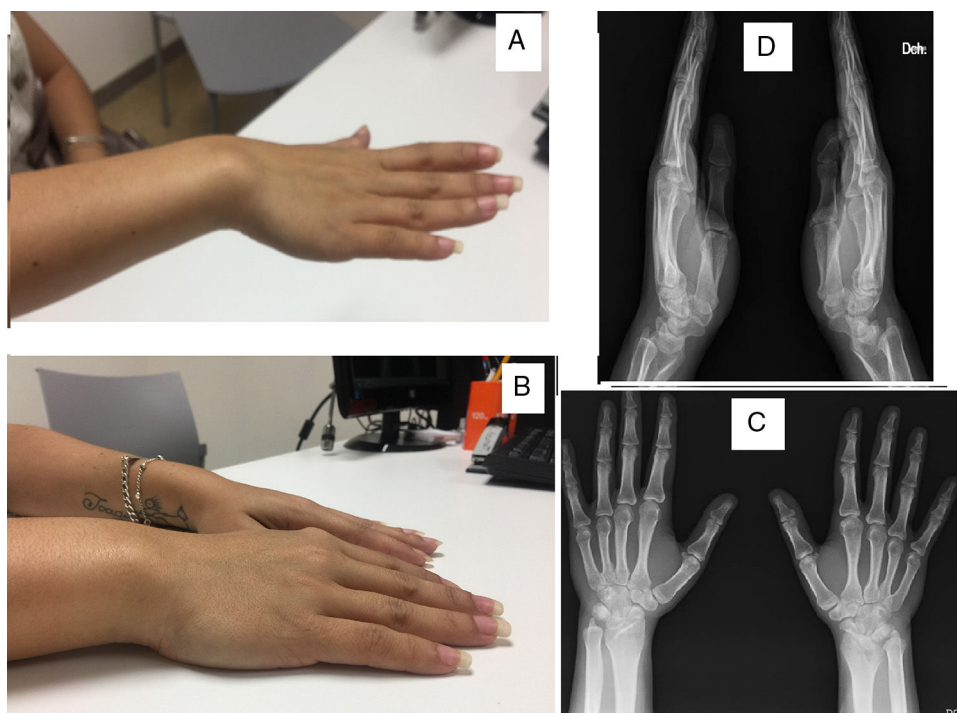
(A and B) Dorsal dislocation of the ulna. (C) Posterior–anterior X-ray of both hands. (D) Lateral X-ray of both hands.
